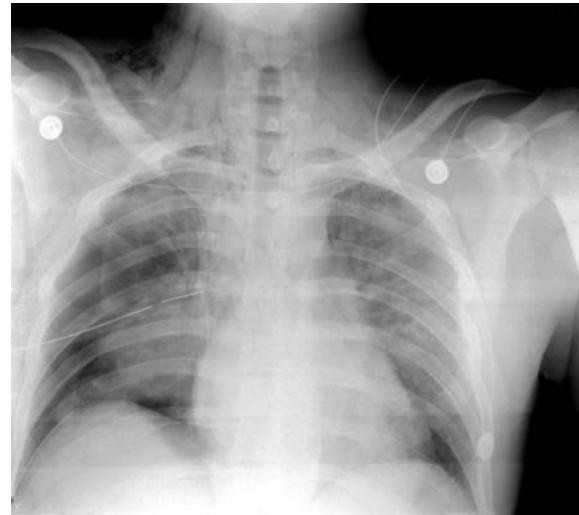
Chest radiograph demonstrating bilateral opacity and pneumothorax due to blast injury.
